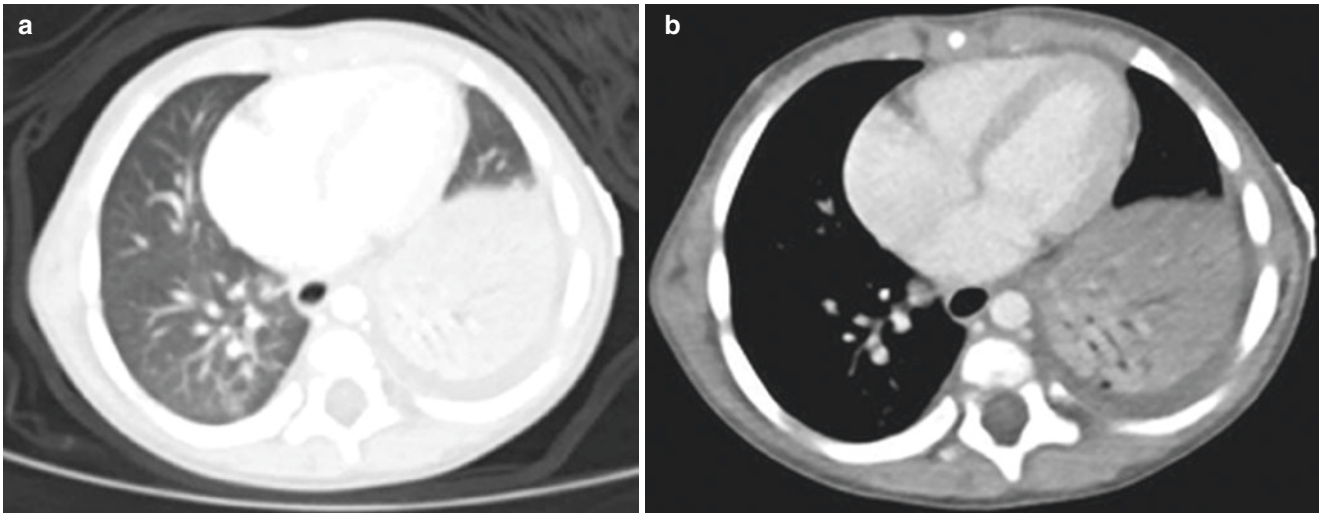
(a, b) Axial CT views of the chest in a patient with necrotizing pneumonia in the left lower lobe and a left pleural effusion, lung (a) and soft tissue (b) windows, using high-pitch protocol. Diagnostic quality images were obtained while minimizing radiation to the patient
